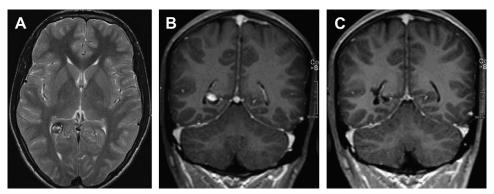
(*A*) T2-weighted axial and (*B*) T1-weighted coronal gadolinium-enhanced MRI of a right temporo-occipital deep-seated cavernoma (*B*) before and (*C*) after complete removal.
